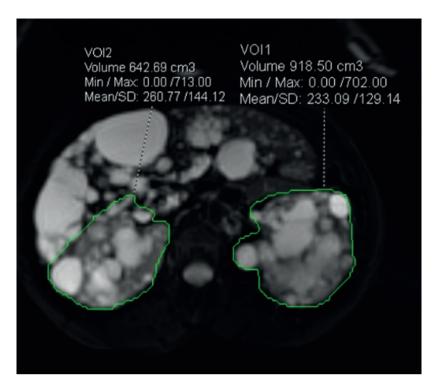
Transverse MRI scan, T2-weighted fat-saturated sequence with renal contours marked
